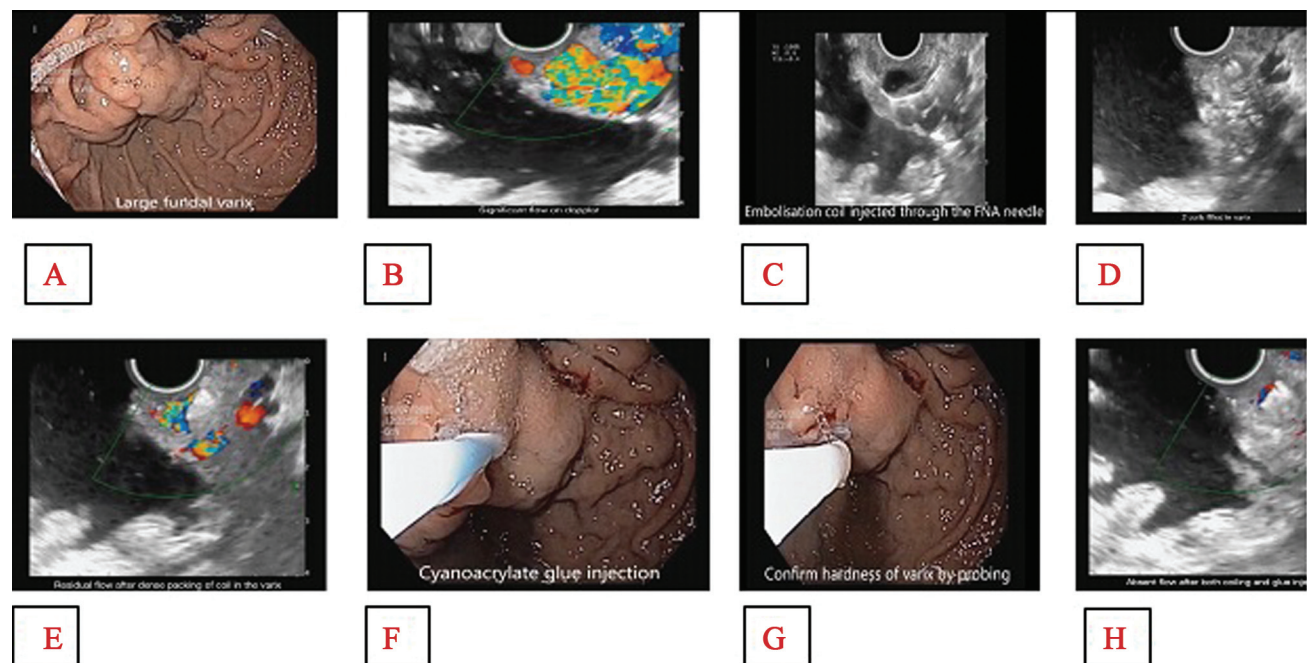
Steps of EUS coiling and glue. (A) Large fundal varix. (B) Significant flow in doppler. (C) Coil injected through FNA needle. (D) Coil inside the varix. (E) Residual flow in varices. (F) Cyanoacrylate glue injection. (G) Confirm hardness of varix by probing. (H) Absence of flow in varix after coiling and glue injection. EUS, endoscopic ultrasound; FNA, fine needle aspiration.
